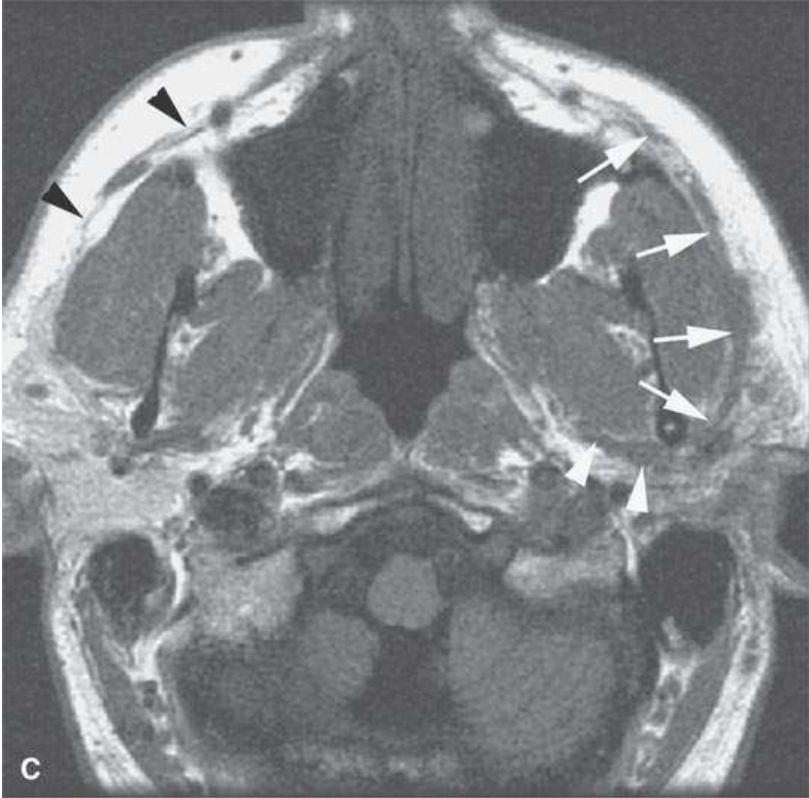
A patient with melanoma of the periauricular region spread along V3 to the trigeminal ganglion proximally. A: Contrast-enhanced computed tomography (CT) showing spread from the auriculotemporal nerve (*arrow*) to V3 (*arrowheads*). B: Continued spread from the main trunk of V3 in the masticator space (*arrow*) to the trigeminal cistern (*arrowheads*). C: Contrast-enhanced T1-weighted (T1W) magnetic resonance (MR) showing trigeminal cistern involvement (*arrowheads*) from V3 spread (*arrows*) to correlate with CT in (B). D: Anterograde spread from the trigeminal ganglion to the pterygopalatine fossa and infraorbital nerve (*arrows*) as well as foramen ovale enlargement (*arrowhead*). E: Contrast-enhanced T1W MR showing trigeminal cistern involvement (*arrow*) with anterograde V2 spread (*arrowheads*).
